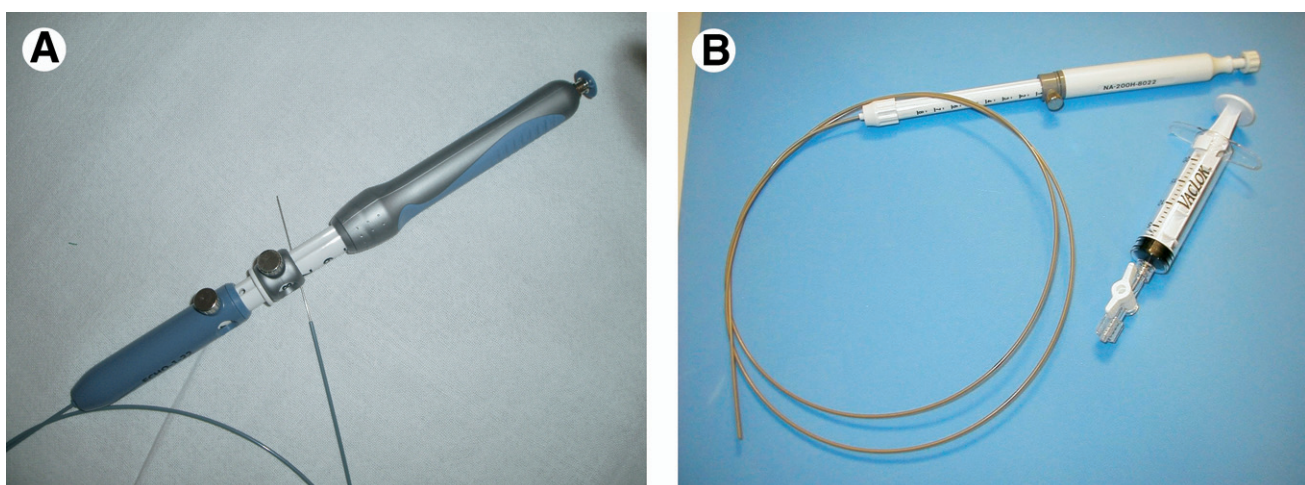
(A) The Echotip Ultra ultrasound needle system (Wilson-Cook) which has a two-stage plastic handle with an ergonomic handle design. (B) The Ezshot needle made by Olympus. (Color version of figure is available online.)
